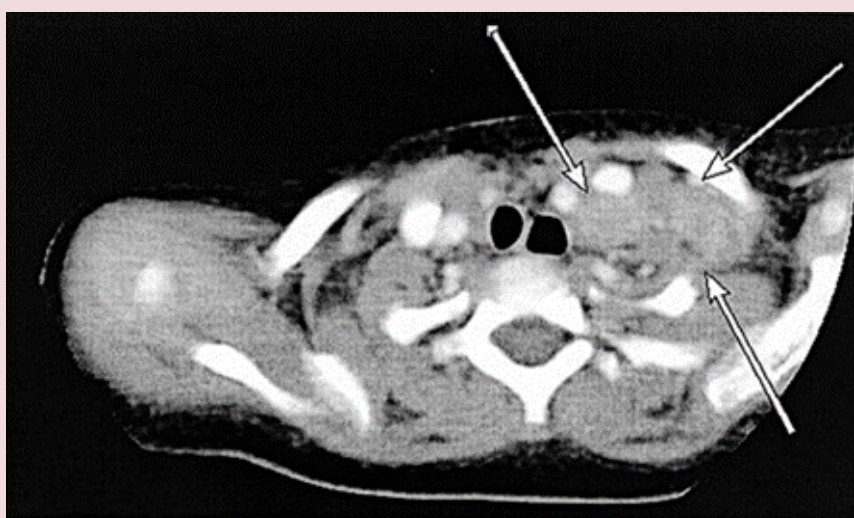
Computed tomography scan of neuroblastoma in a child
